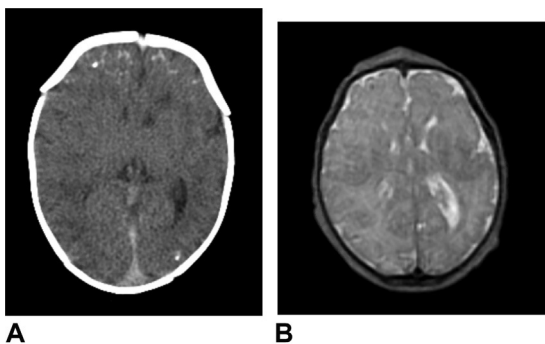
(A) Noncontrast head CT of 4-day-old patient with congenital Zika. This motion degraded head CT demonstrates bifrontal and left parietal cortical and subcortical calcifications. Not shown is the T1 MRI brain with corresponding hyperintense signal. (B) Axial T2 MRI brain of 1-day-old patient with congenital Zika. The left cerebral hemisphere is mildly decreased in volume compared to the right; there are abnormal sulci and broadened gyri in the left frontoparietal regions suggesting pachygyria; there is an abnormally thickened and irregular cortex in the posterior left sylvian fissure suggesting cortical migration anomaly.
